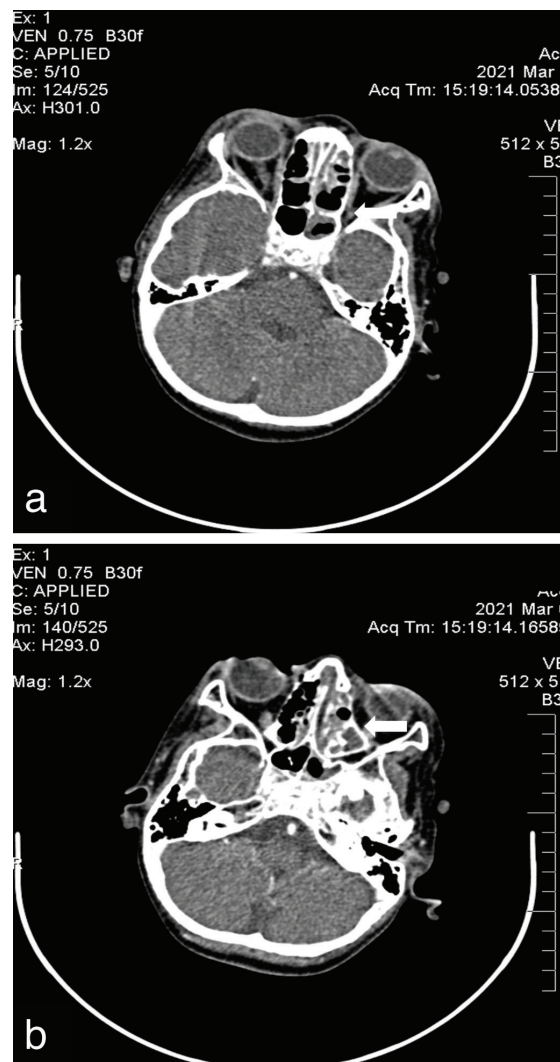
Brain computed tomography of the patient. Sinus involvement was noted
